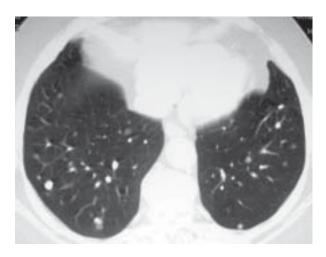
HRCT after treatments light regression of pulmonary changes was seen
